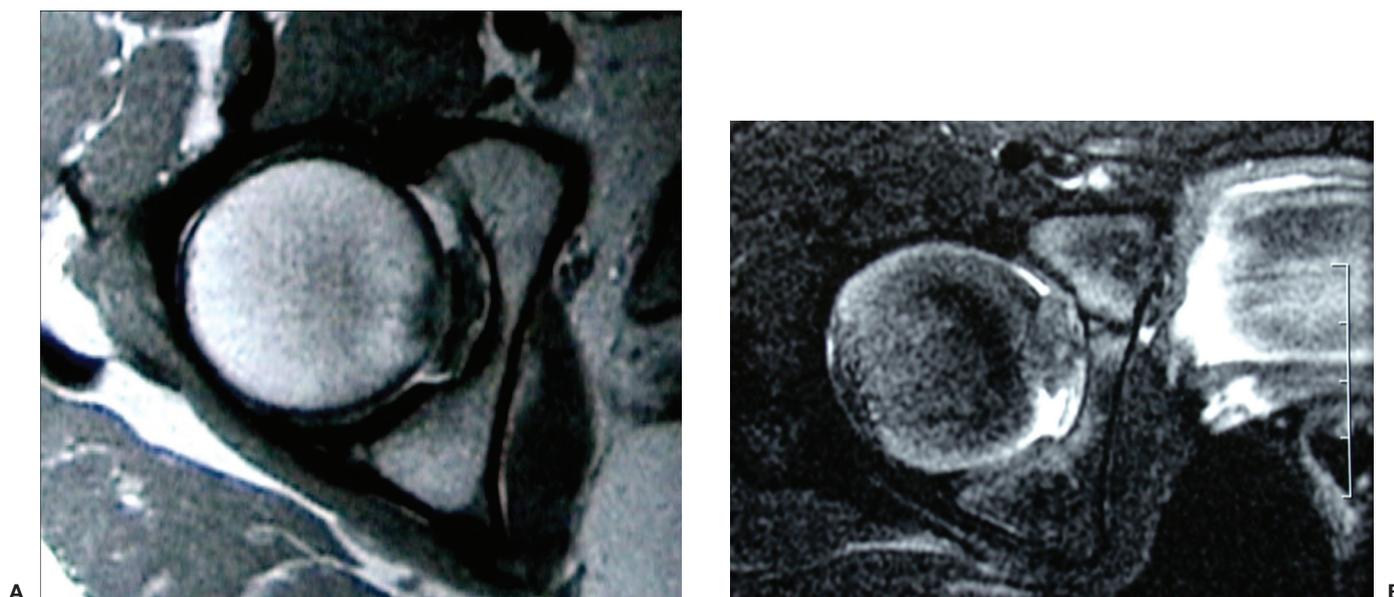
Ligamentum tears are best visualized on axial MRI images. T1 image (A) shows ligamentous discontinuity (arrow) and a T2 image (B) often reveals corresponding fluid within the fovea.
